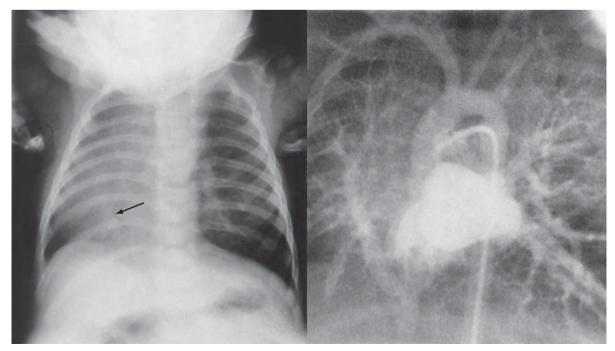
Scimitar syndrome. Chest radiograph (*left*) demonstrating the scimitar-shaped shadow (*arrow*) that represents the anomalous vein and gives the syndrome its name. Angiography (*right*) subsequently confirmed this shadow to be the scimitar vein draining the right lung anomalously to the inferior vena cava.
